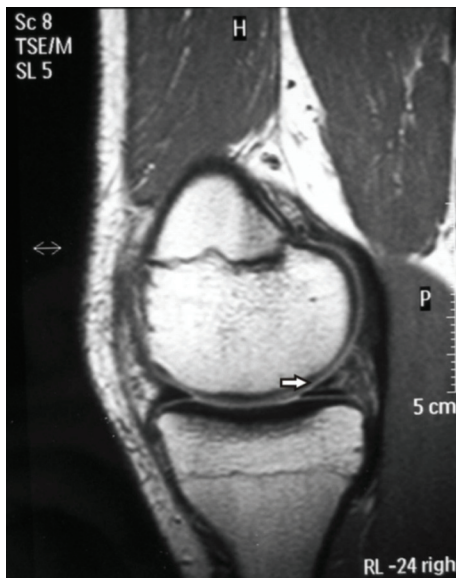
Sagittal fast spin-echo T2 weighted MRI demonstrated superior flap tear of the medial meniscus (arrow).
